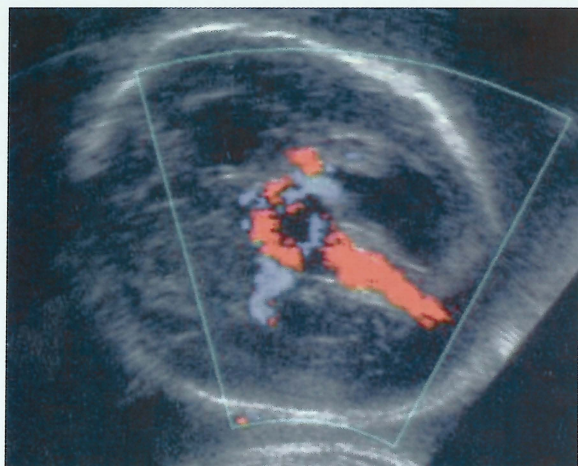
Doppler examination in utero revealed the dilatation of the Galen vein and the increased blood flow within the venous pouch and the falcine sinus.
